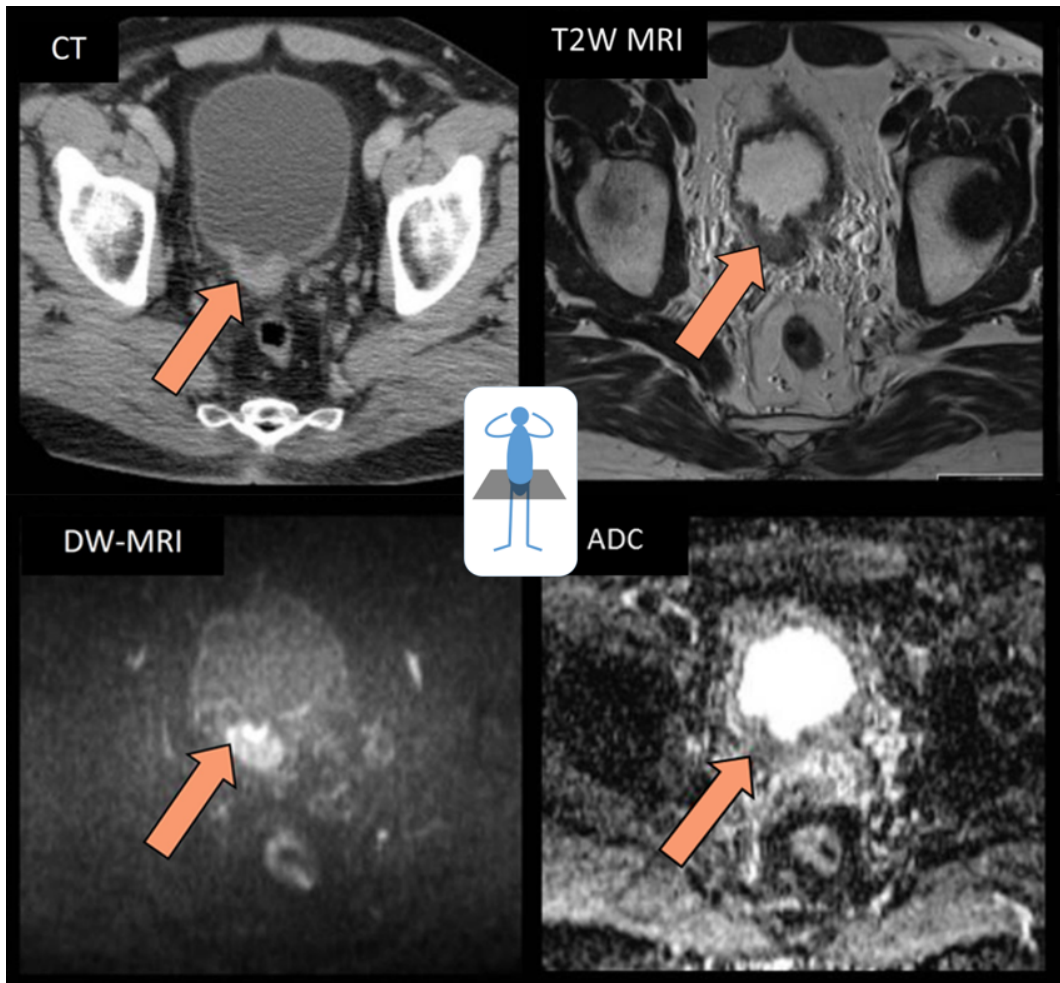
Cross-sectional imaging of the bladder and an internal tumour as shown using CT,  $T_2$ -weighted MRI ( $T_2$ W-MRI), Diffusion-weighted MRI (DW-MRI) and Apparent Diffusion Coefficient (ADC) mapping. Images reproduced from Maurer et al. [23], arrows added.
